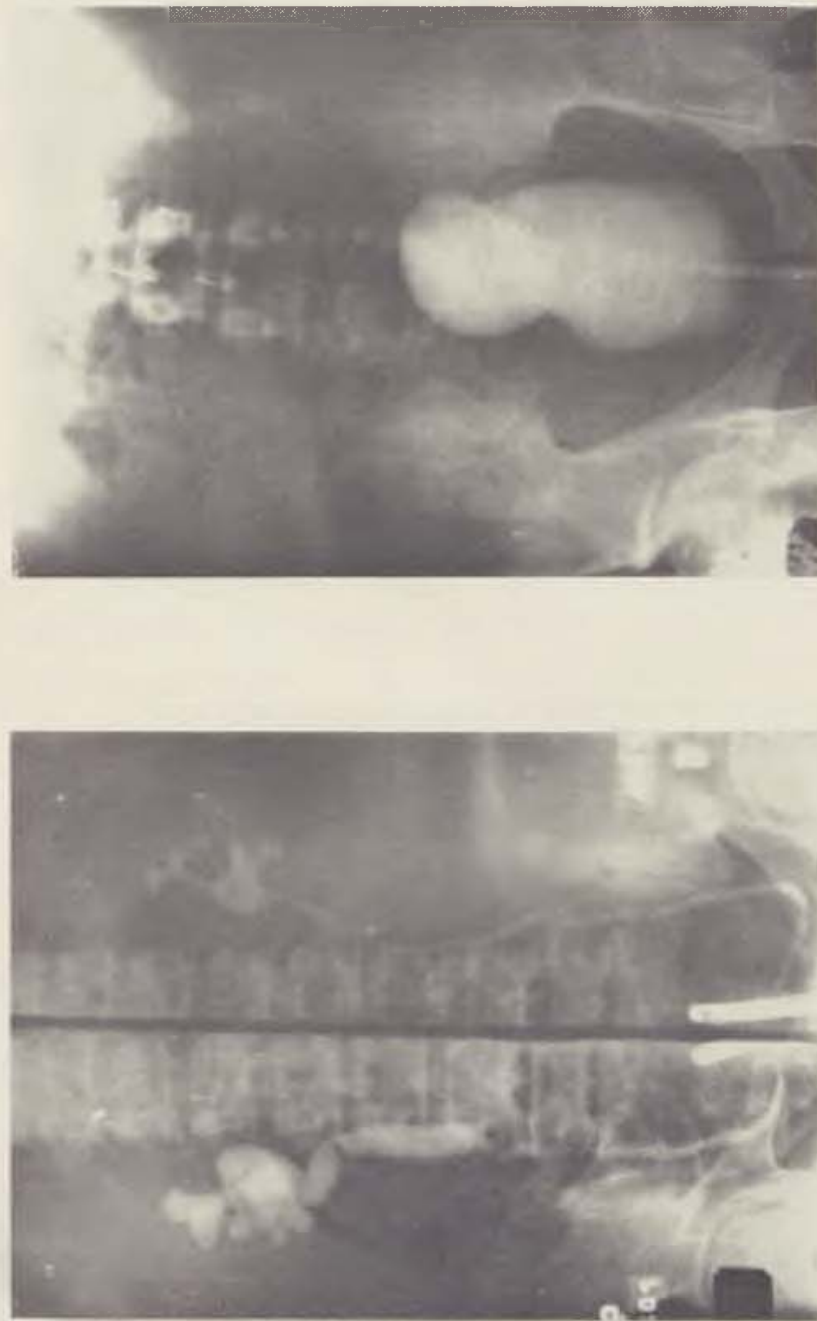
Bilateral retrograde uretero-pyelography in patient T., woman aged 38, prior to operation: Stricture of middle part of right ureter, above stricture dilatation of ureter, pelvis and calyces of kidney. On the left ureter appears normal. — Fig. 4. Cystography in patient A., man aged 21, after autogenous reconstruction of lower half of left ureter. X-ray 15 days after operation
